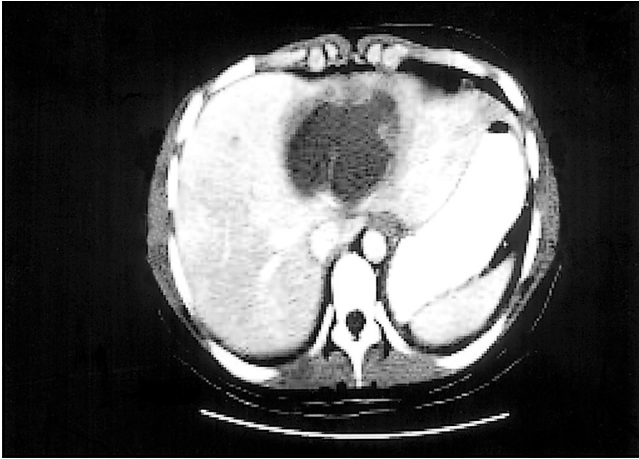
CT scan showing a large left-lobe amebic liver abscess.
